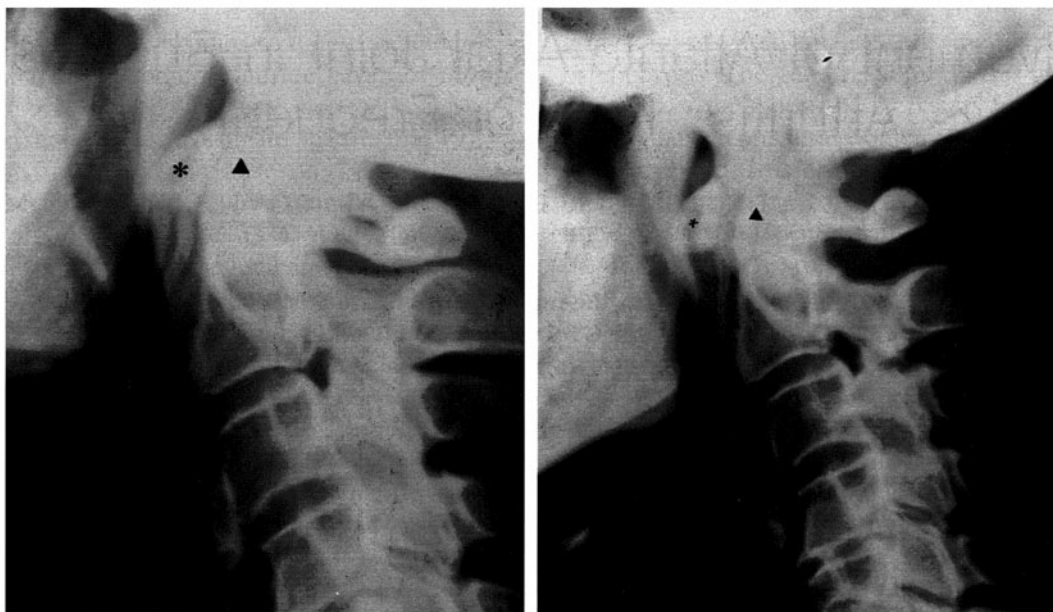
Slight lesion: 68-year-old male with an 8-year history of RA. Conventional radiographies with dynamic projection :
